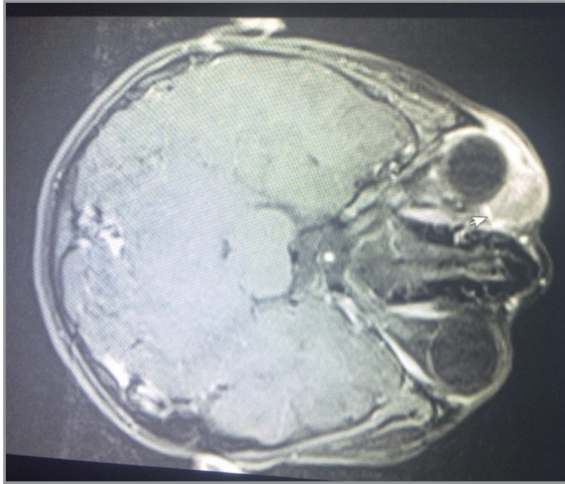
Magnetic resonance imaging (MRI) of the eye; a mass lesion of soft tissue in the upper right palpebra, which showed heterogenous and intensive trapping of contrast that was hypo-intense in T1A (arrow).
